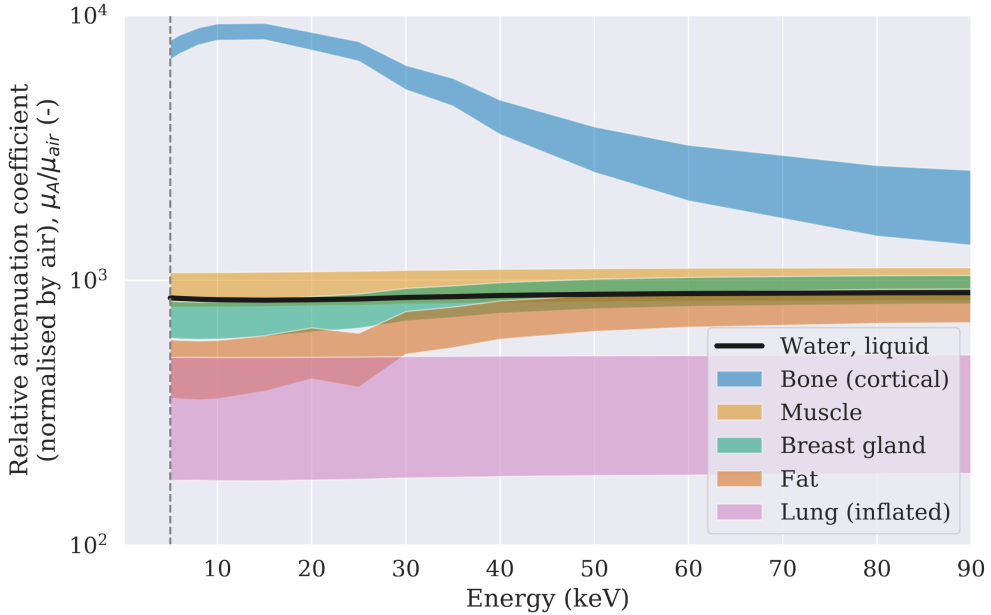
The photon attenuation coefficients for several biological materials from 5 to 90 keV. The data used in these plots are from NIST’s x-ray mass attenuation coefficient table four. The error bands used are the 3σ values from the tissue density database compiled by the IT’IS Foundation (The Foundation for Research on Information Technologies in Society) (62). The vertical grey dashed line at 5.0 keV indicates the approximate minimum achievable energy threshold with Medipix3 with a silicon sensor.
